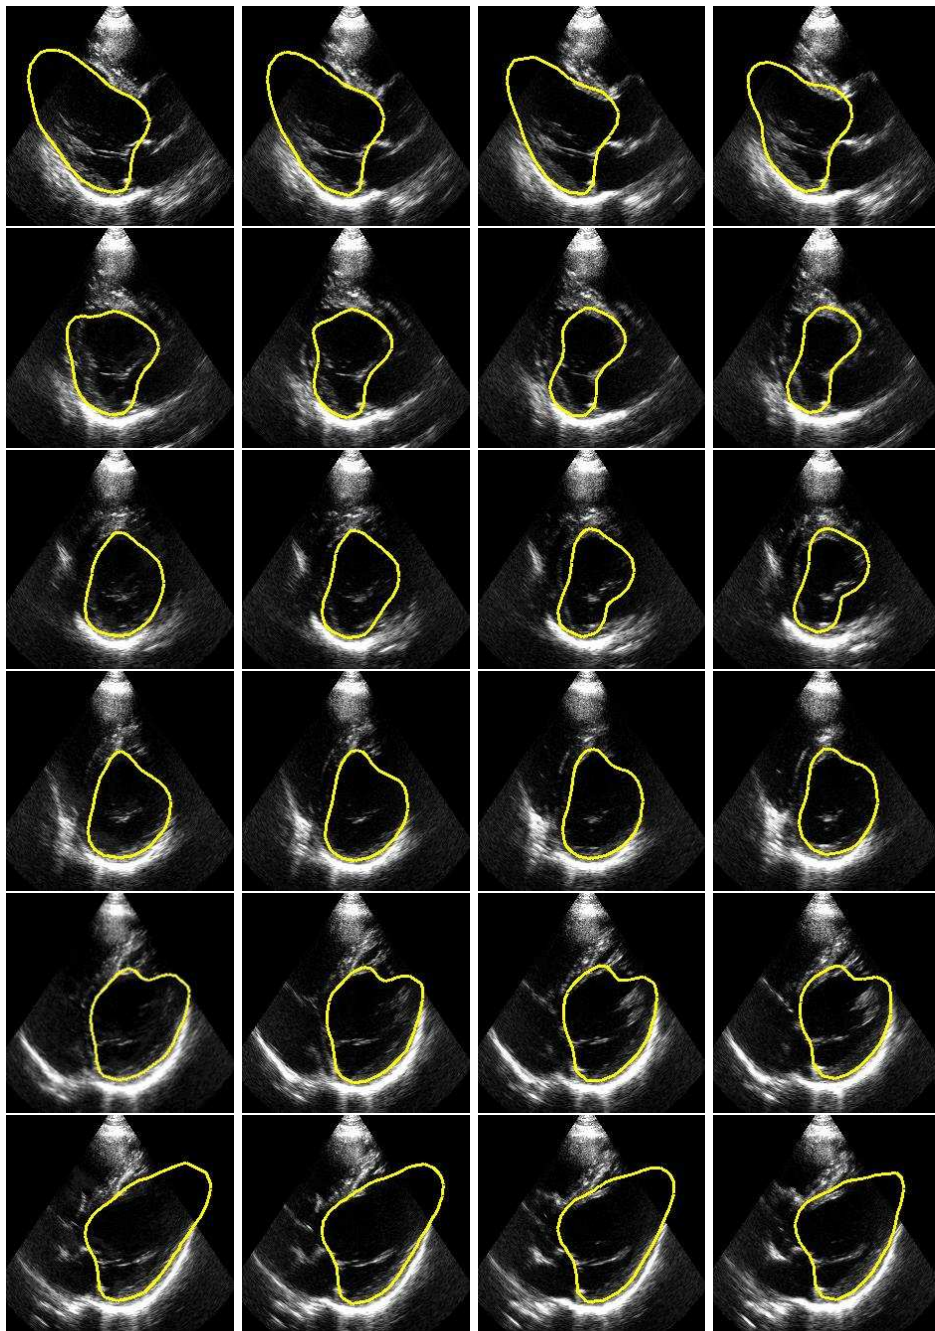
Ultrasound image slices with the intersections of recovered ventricle model. The horizontal direction corresponds to time while the vertical direction corresponds the different slice planes.
